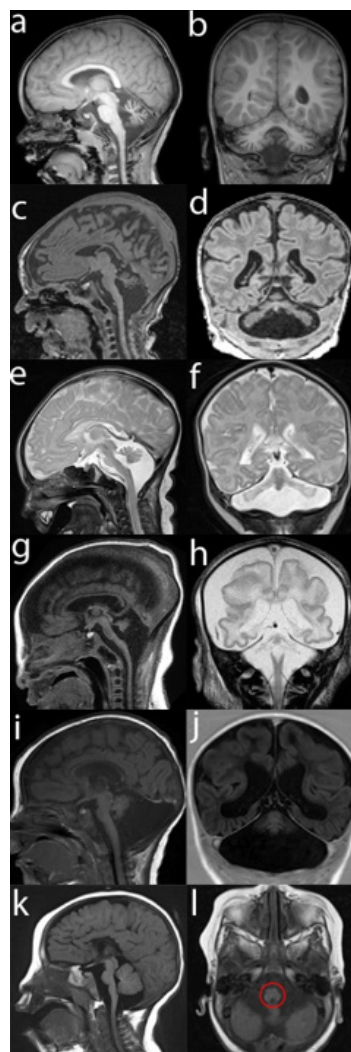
MRI images of PCH patients in sagittal (a, c, e, g, i, k), coronal (b, d, f, h, j), and axial (l) cross sections. MRI 'a' and 'b' display a PCH1B patient with the mild phenotype correlating with the p.(Asp132Ala) change in the *EXOSC3* gene. Other mutations in *EXOSC3* are associated with more severe atrophy of pons and cerebellum ('c', 'd'). PCH2A ('e-f') and PCH4 ('f-h'), both caused by *TSEN54* mutations, display the classical 'dragonfly' pattern seen on the coronal MRI ('f', 'h'); however, in PCH4 more cerebral involvement is seen. *TOE1* mutations cause PCH7 with severely dilated ventricles ('i', 'j'). *AMPD2* mutations cause PCH9 ('k', 'l'), which show a typical 'figure 8' pattern of the midbrain on the axial MRI ('l', red circle).
